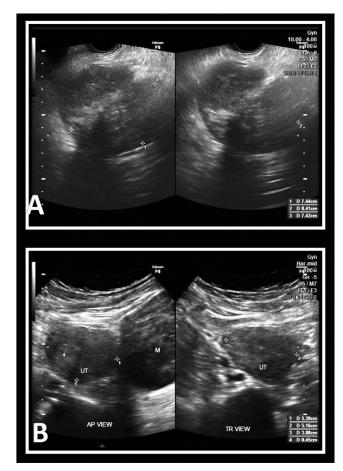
A transvaginal ultrasound of the uterus and pelvic mass. The normal-sized uterus (UT) was anteverted, measuring 5.38x5.16x3.88cm and has a huge, pedunculated mass (M) at the left isthmic area (A, upper panel). The pelvic mass was bilobed, measuring 7.44x8.41x7.42cm with mixed echogenicity (B, lower panel)
